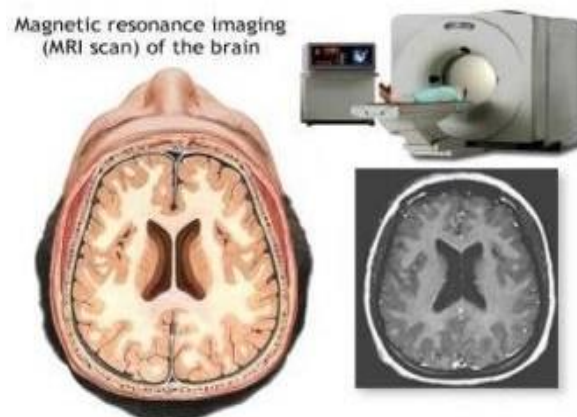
MRI of the brain [V. Vijaya Kishore and V. Kalpana et.al. (2019)]
